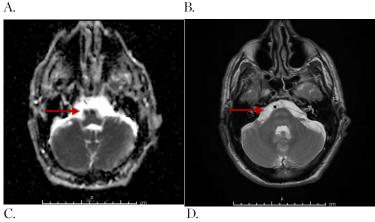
Axial MRI of the brain obtained 36 hours after admission demonstrates (by red arrows) symmetric areas of increased signal in diffusion weighted imaging (A, B) with decreased signal in apparent diffusion coefficient (C) and high T2 signal (D) at the level of the medullary pyramids and caudal pons involving predominantly white matter tracts.
